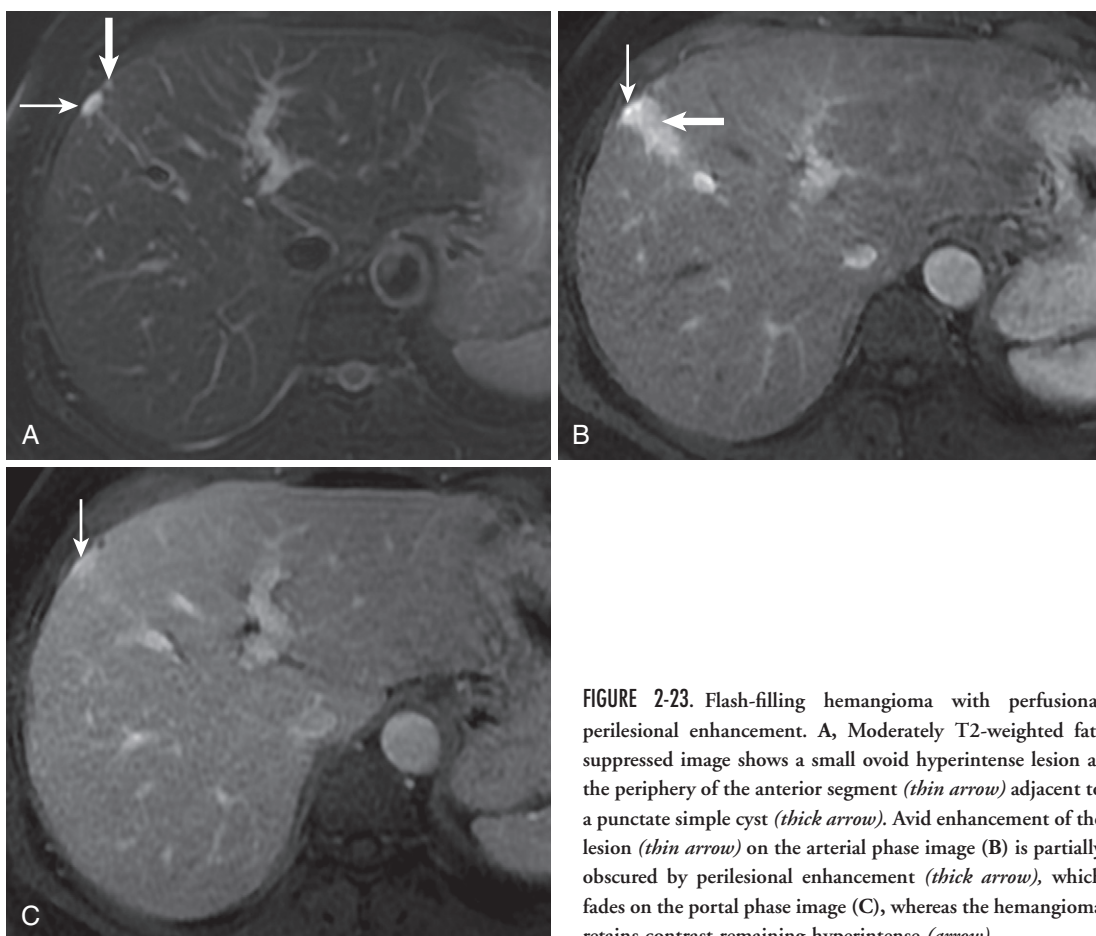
Flash-filling hemangioma with perfusional perilesional enhancement. A, Moderately T2-weighted fat-suppressed image shows a small ovoid hyperintense lesion at the periphery of the anterior segment (*thin arrow*) adjacent to a punctate simple cyst (*thick arrow*). Avid enhancement of the lesion (*thin arrow*) on the arterial phase image (B) is partially obscured by perilesional enhancement (*thick arrow*), which fades on the portal phase image (C), whereas the hemangioma retains contrast remaining hyperintense (*arrow*).
